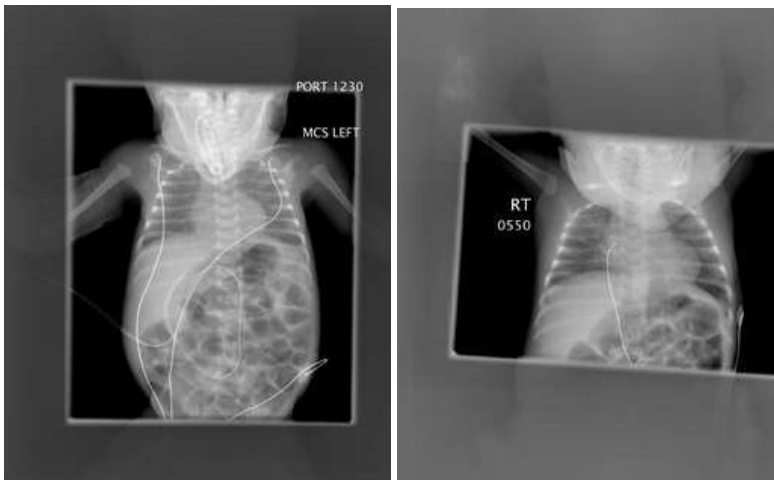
Chest X-ray of a one month old female patient with BPD.
